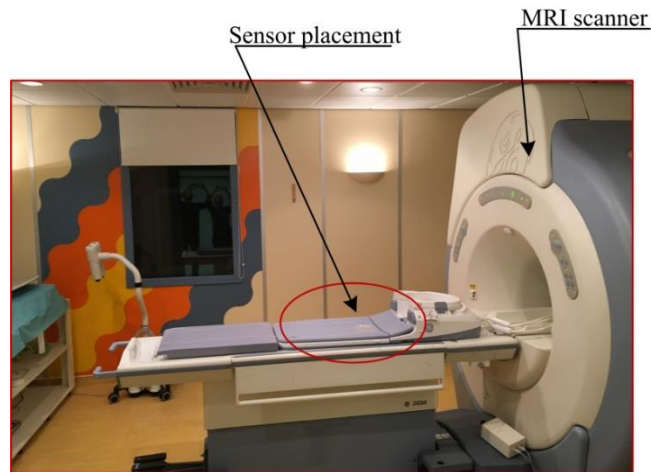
Implementation of the sensor on the patient part during the MRI examination.
